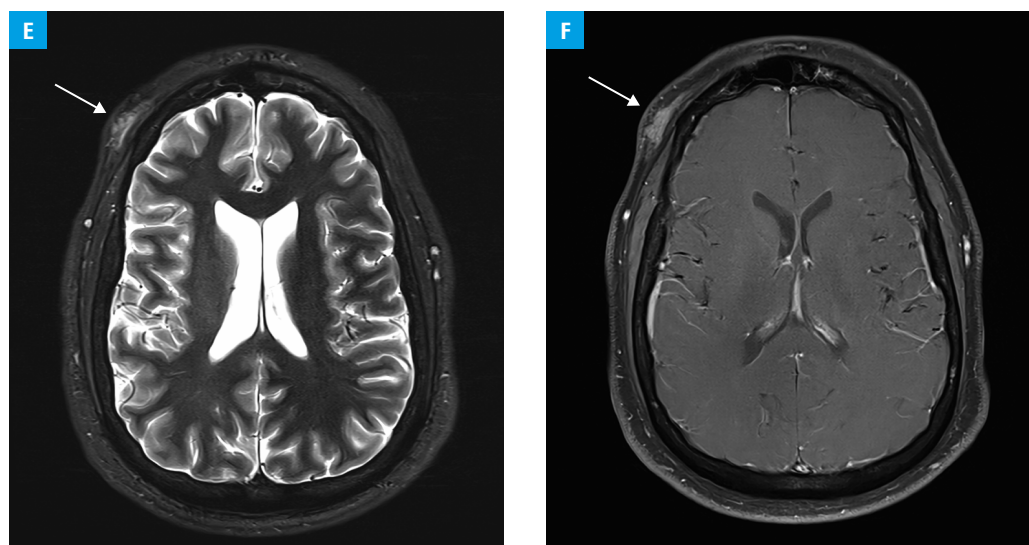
E, F – magnetic resonance imaging of the cranial arteries showing pseudoaneurysm of the right temporal artery (arrows; E – T2-weighted sequencing; F – fluid-attenuated inversion recovery sequencing)
